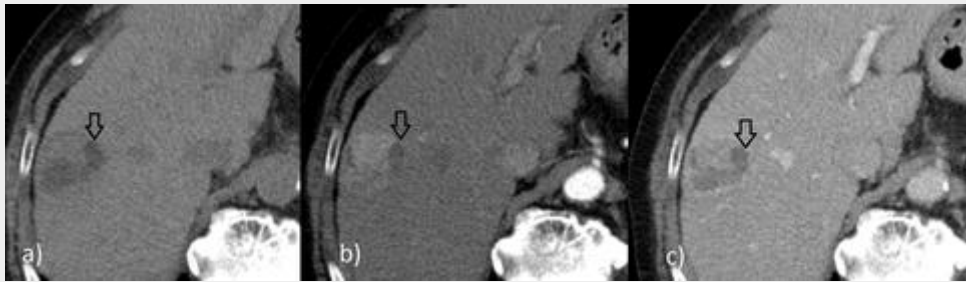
CT axial images non-enhanced (a) and after contrast in arterial (b) and portal phase (c) in a patient with hepatocellular carcinoma. There are focal intralesional areas of lower attenuation (negative HU values) which don't enhance after contrast (black arrow) corresponding to fat. Other portions of the lesion are hypervascular (b) with washout in portal phase (c).
